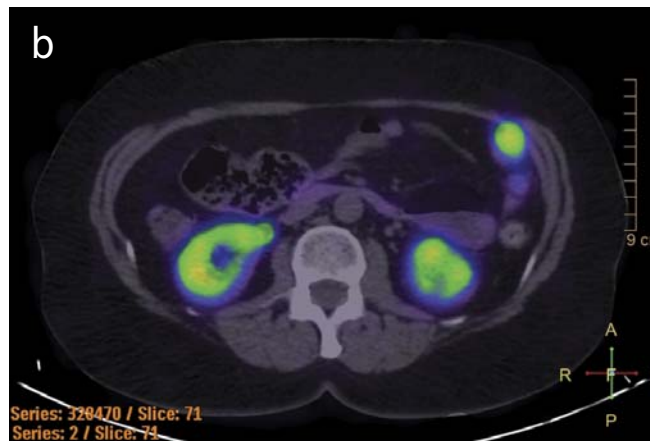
^{68}Ga -DOTA-NOC PET/CT presented three abdominal lesions (a, b, c) with high somatostatin-receptor density and therefore suspicious of NET metastases. As tissue of the spleen presents high somatostatin receptor density, this pitfall arose from splenosis which was unknown at this point of time.
